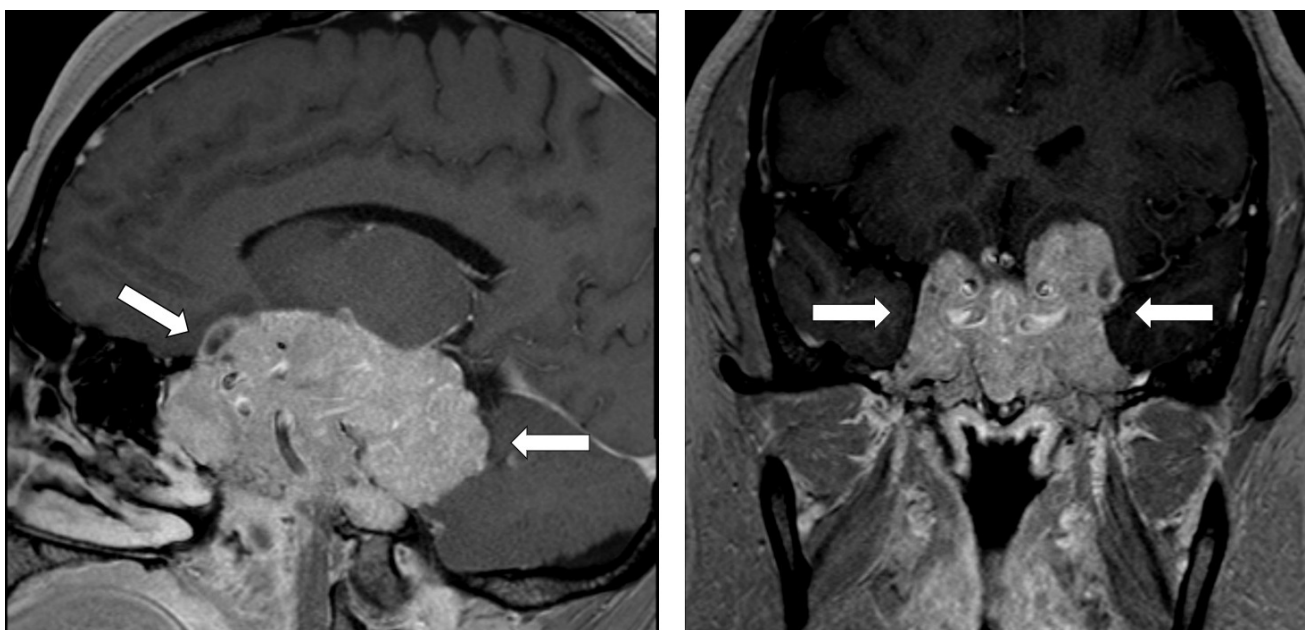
MRI of the pituitary gland (T1-weighted sagittal and coronal views) demonstrating a giant prolactinoma with extensive sellar and suprasellar involvement and posterior fossa extension (see arrows).
